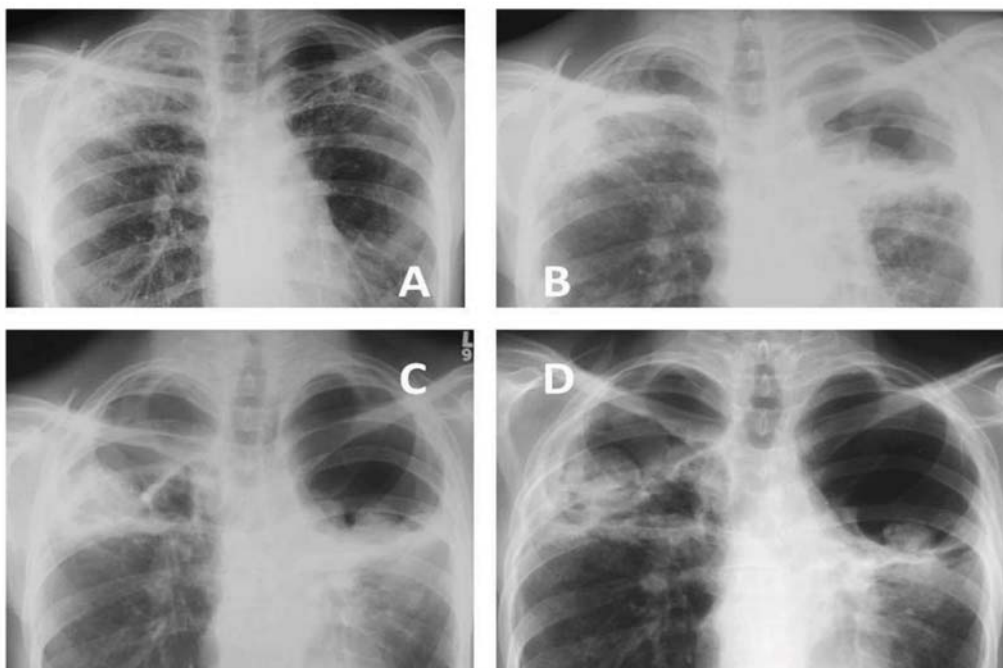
Serial chest X-rays of a patient with chronic cavitating pulmonary aspergillosis. (A) January 2001; (B) February 2002; (C) April 2003; (D) July 2003.
